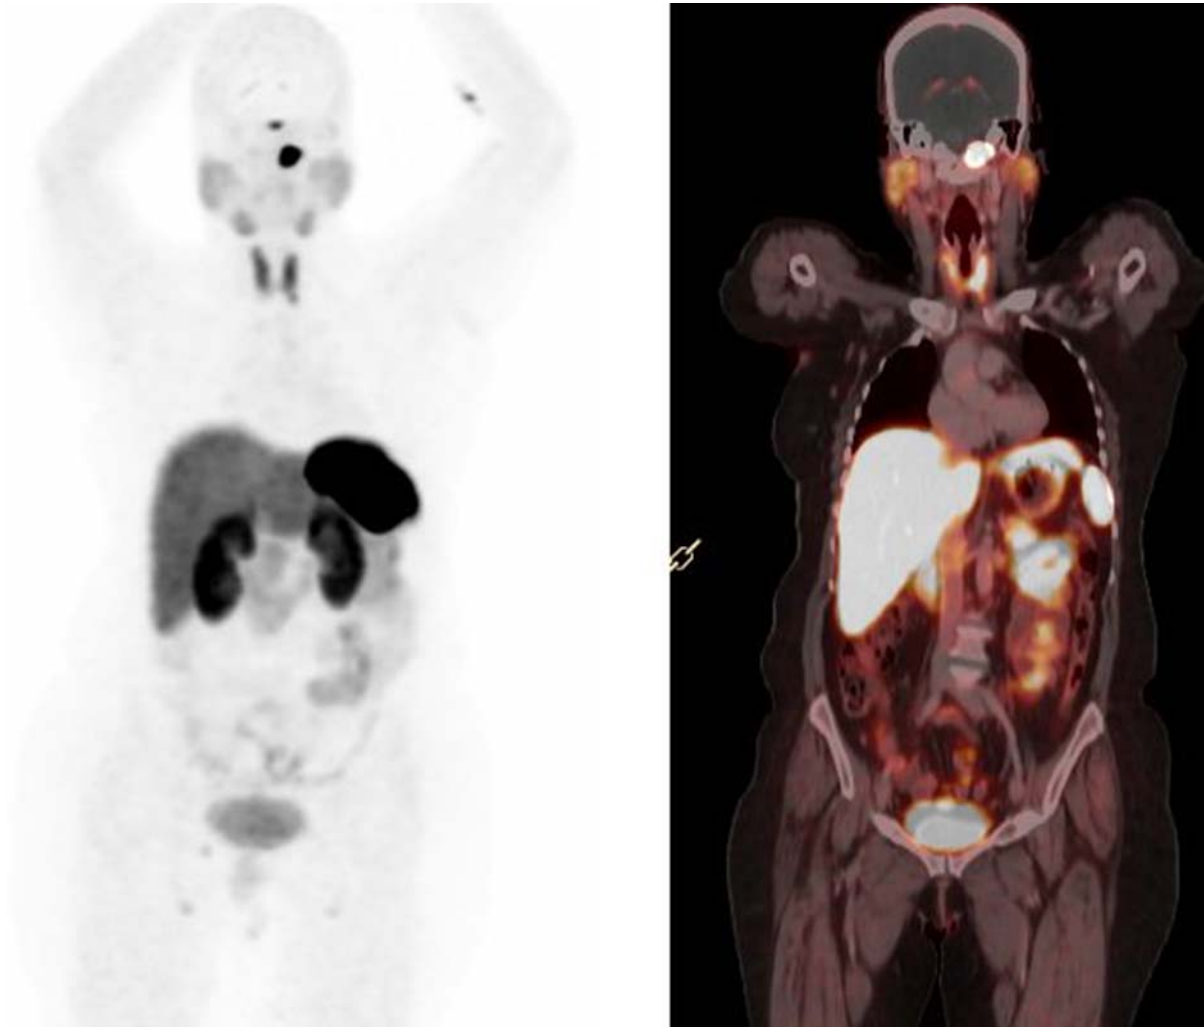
^{68}Ga -DOTATATE PET-CT (MIP and fused coronal view) demonstrating enhancing soft tissue lesion (2.3x1.9x2.1 cm) in the left basiocciput and left occipital condyle involving the left jugular foramen and left jugular foramen
